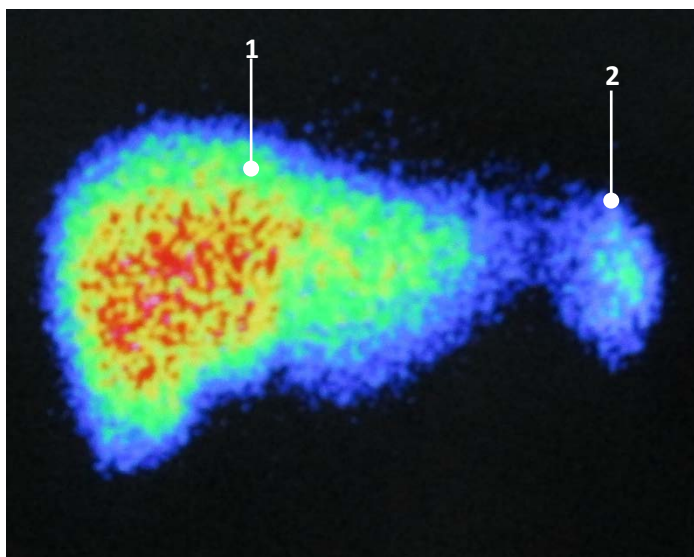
Static scintigraphy of liver. Normal distribution of $^{99\text{m}}\text{Tc}$ -labeled colloid in liver (1) and spleen (2)
